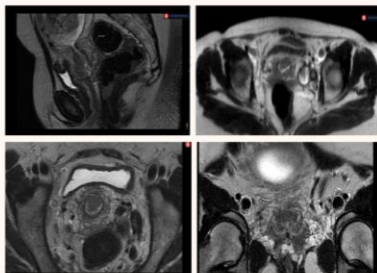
MRI-TAP identifies an expansive/neoepithelial lesion measuring 30 × 20 × 19 mm, with no invasion of the parametria or extension to the vaginal vault, and no lymphadenopathy with pathological characteristics in the pelvic chains (stage IB2).
